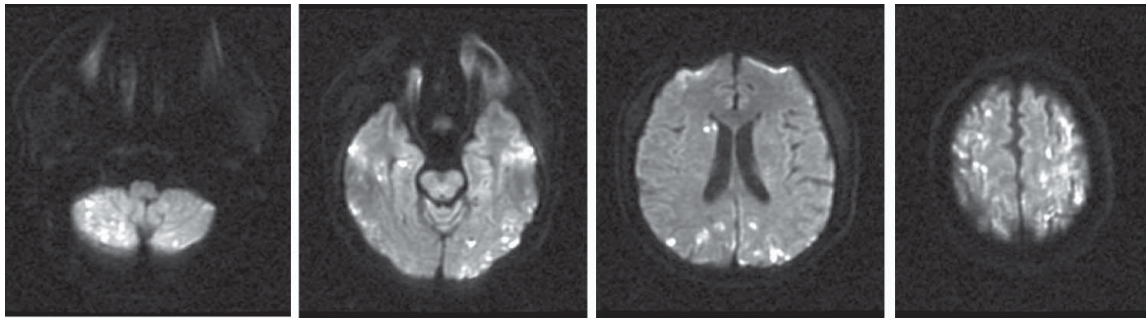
Diffusion-weighted magnetic resonance imaging revealed multiple infarcts of bilateral cerebral and cerebellar hemispheres, cortically and subcortically.
